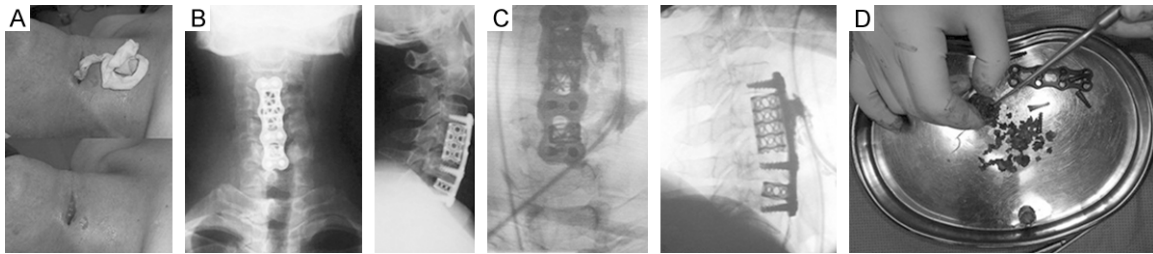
Patient's conditions 4 d after the operation. A: The patient's body temperature rose to 38.2°C and swelling appeared around the wound with the overflow of stink dark red pus. B: The patient presented with hyperpyrexia and wound exudates, and frontal and lateral X-ray re-examination of the cervical vertebrae did not show apparent abnormal changes, such as internal fixation loosening and translocation. C: A slit pore in the deep fascia connected to the deep tissue and contrast aggregation around the plate and titanium mesh were observed during debridement. D: The plate and titanium mesh were removed during debridement, and bone graft particles released a foul odor.
